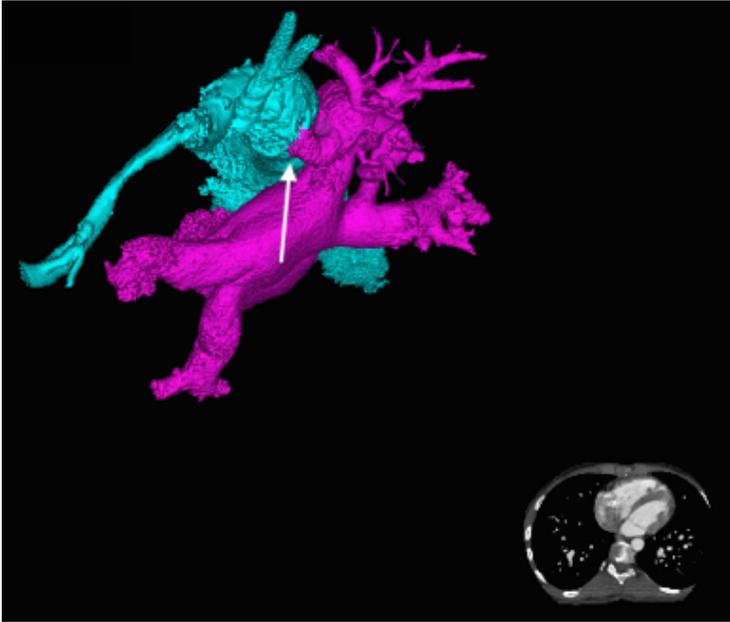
CT 3D reconstruction demonstrating connection of the vertical vein to the superior vena cava (white arrow).
